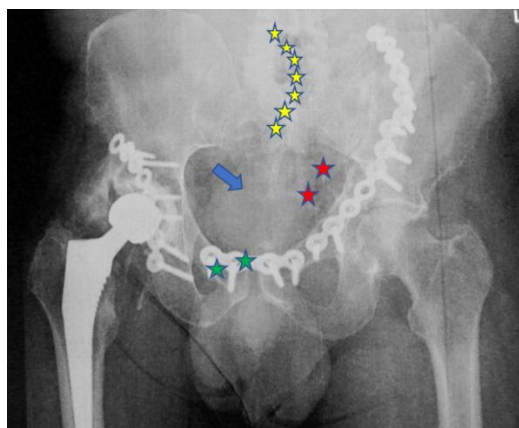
Figure V (Case one): Antero-posterior pelvic X-ray taken at 4-months post operatively, demonstrating both fracture union and satisfactory pelvic alignment. The pubic symphysis plate and right sided hybrid total hip replacement augmented by a posterior acetabular pelvic reconstruction plate are clearly visualized. On the left side the 2 screws fixing the pelvic reconstruction plate medial to the superior pubic ramus fracture line, can be seen (green stars). The 2 empty holes are then visualized as the plate passes over the fracture line on the superior pubic ramus (blue arrow). Once across this fracture line the same plate is secured with 2 screws into the dense supra-acetabular bone (red stars). The pelvic reconstruction plate is then coursed superomedial crossing the fracture line on the iliac crest and secured medially in a curvilinear manner to increase the pull-out strength with 7 additional screws (yellow stars).
